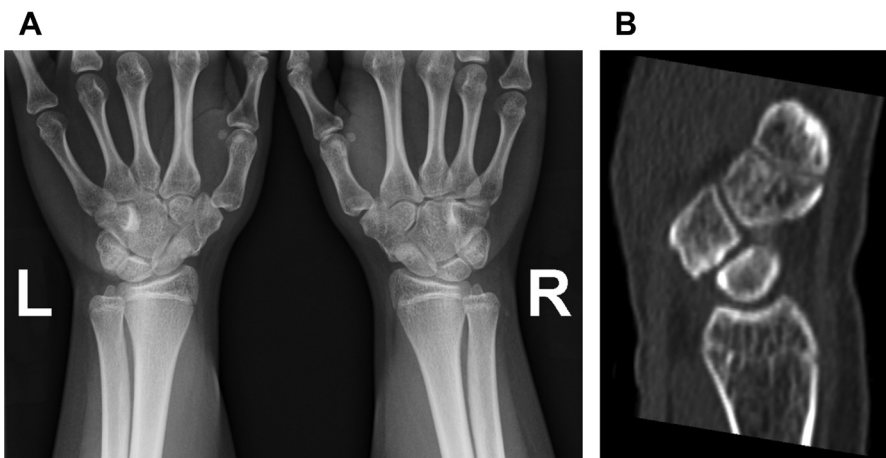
Bipartite scaphoid. (A) Anteroposterior radiographs show bilateral bipartite scaphoids. (B) This is confirmed on sagittal computed tomography image. (Courtesy of Shriners Hospital for Children Philadelphia.)
